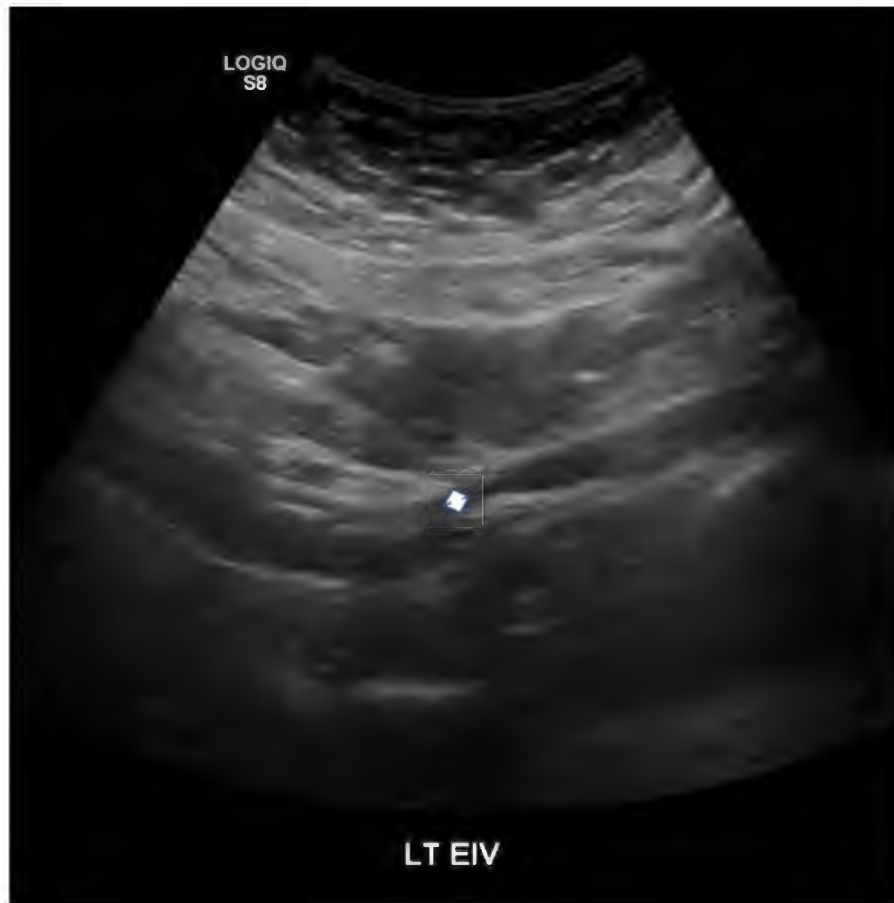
Duplex ultrasound B mode transverse image of the left external iliac venous stent segment demonstrating severe in-stent restenosis with calcification (near occlusion). The white arrow depicts the remaining trickle flow channel.
